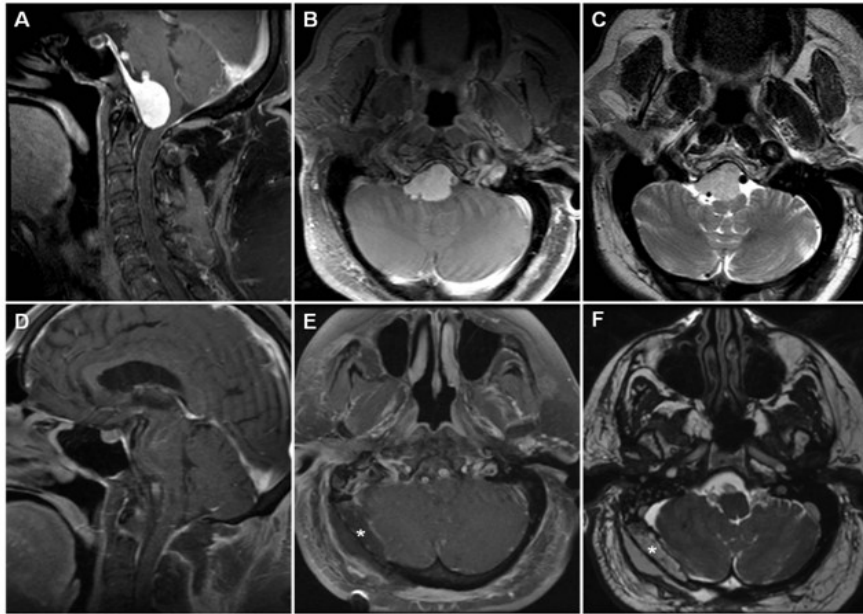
A-C: Preoperative MRI (A: T1 post-gadolinium sagittal, B: T1 post-gadolinium axial, C: T2 axial) demonstrating a ventral foramen magnum meningioma compressing the brainstem. D-F: Postoperative MRI (A: T1 post-gadolinium fat-suppressed sagittal, B: T1 post-gadolinium fat-suppressed axial, C: T2 FIESTA axial) showing complete tumor removal via a right far lateral transcondylar approach. The fat graft (asterisk) is seen filling the dead space of the craniectomy defect and upper cervical musculature.
